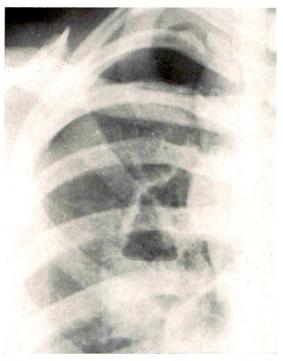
Case I. Roentgenogram made I week later shows clearing of the hazy densities but now there is formation of a traumatic cavity containing liquid blood and trapped air.
